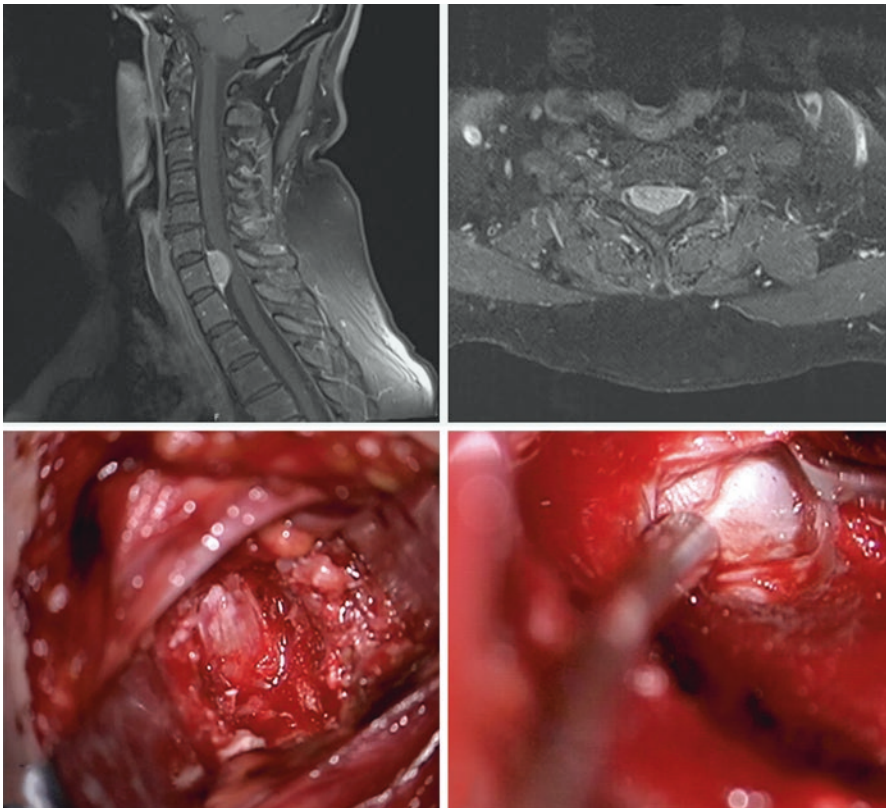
(a) Preoperative sagittal MRI of an intradural meningioma which is located anterior to the spinal cord. (b) The T2 axial contrast-enhanced MRI revealing a broad-based extramedullary mass lesion which is compressing spinal cord posteriorly. (c) Intraoperative view that is showing the dural protrusion anteriorly following C7 corpectomy and removal of anterior longitudinal ligament. (d) Intraoperative view of the meningioma following dural opening
